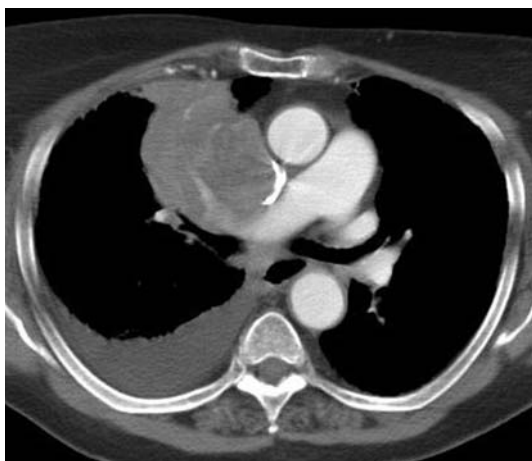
Contrast-enhanced CT demonstrating a mediastinal soft tissue mass obstructing the SVC and coexistent right pleural effusion
